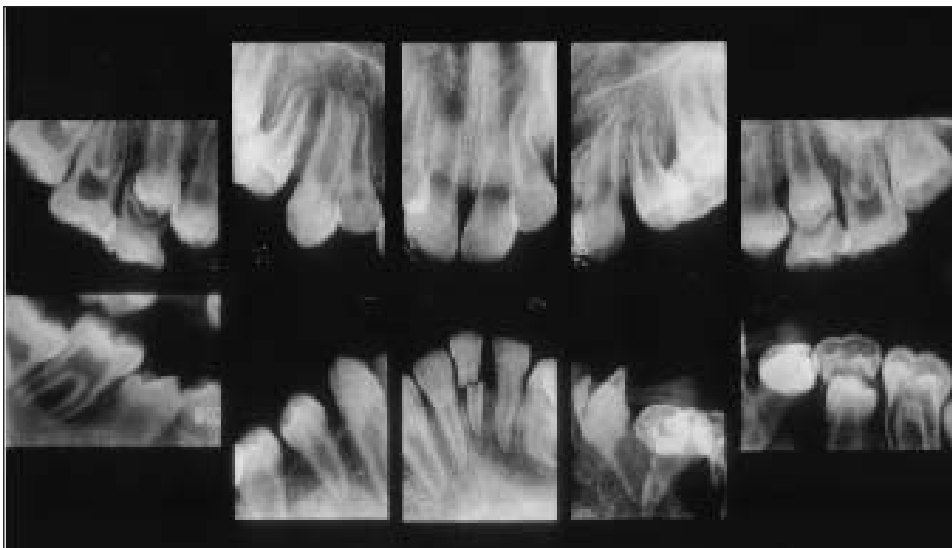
Dental radiographs at first examination.
